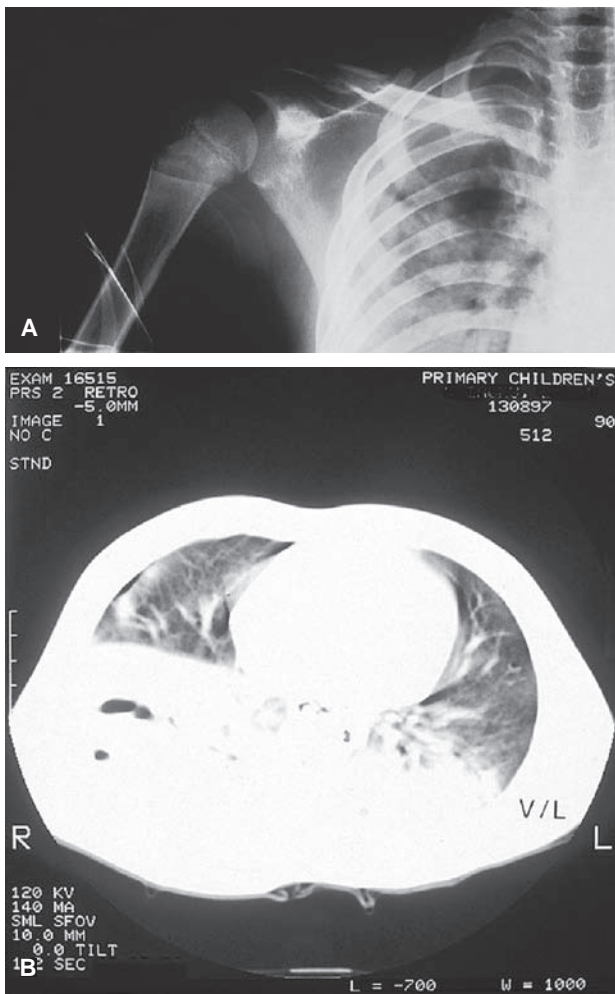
A 7-year-old involved in an automobile–pedestrian accident. Crepitus and decreased breath sounds were noted on the right side. Chest radiograph (A) shows rib fractures, clavicle fracture, and a pulmonary contusion. A pulmonary contusion and a pneumothorax are seen on the thoracic computed tomography (B).
